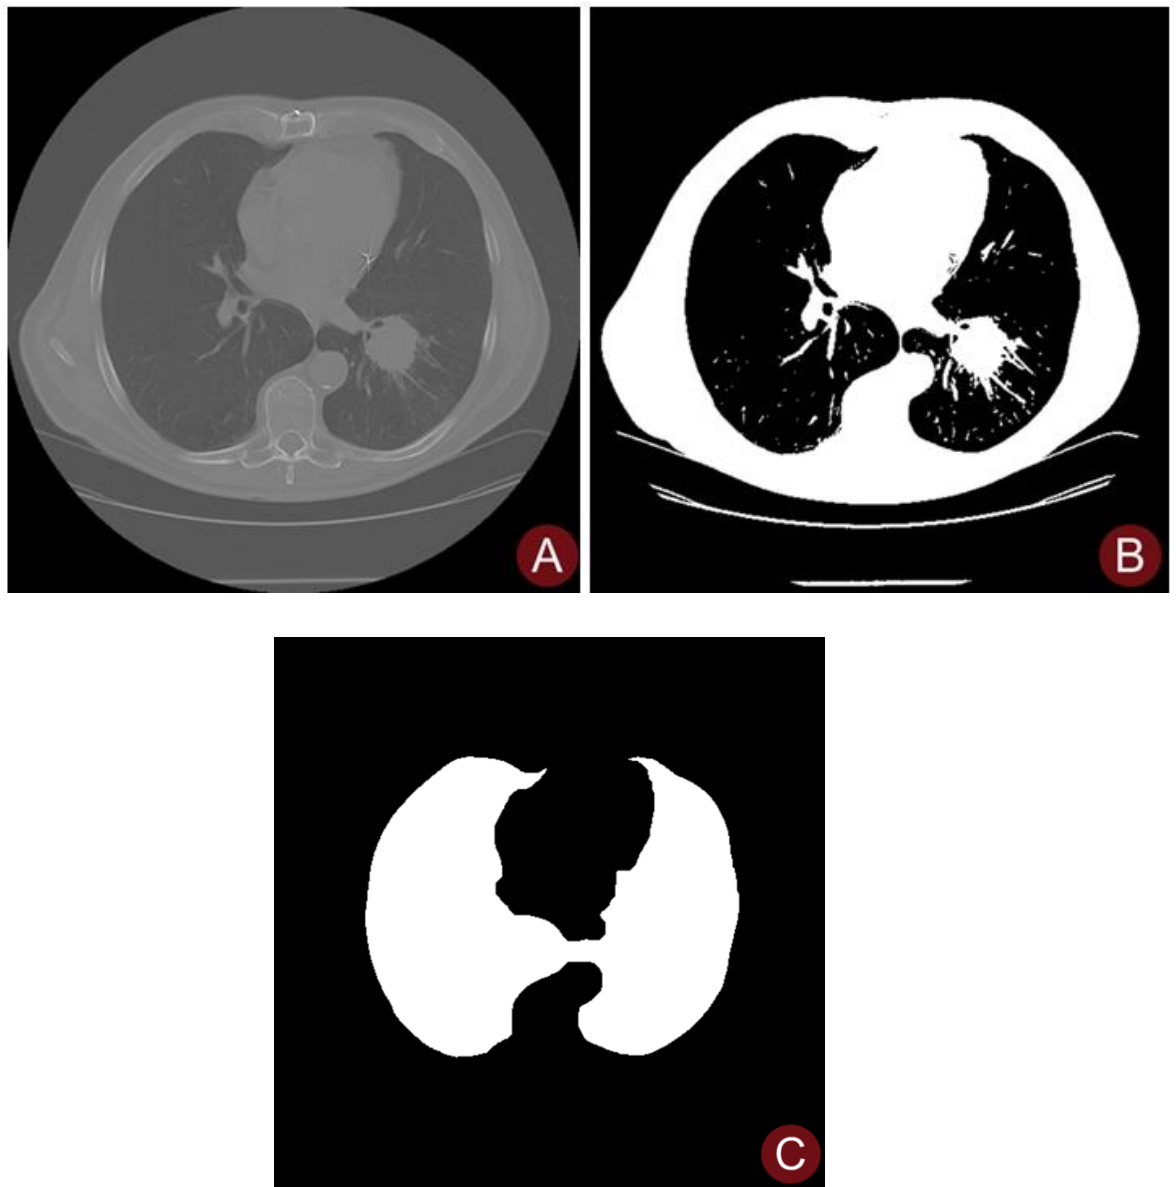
Extraction of processing of lung mask A) An axial slice of a chest CT image. B) Threshold image. C) mask image without any vessels.
